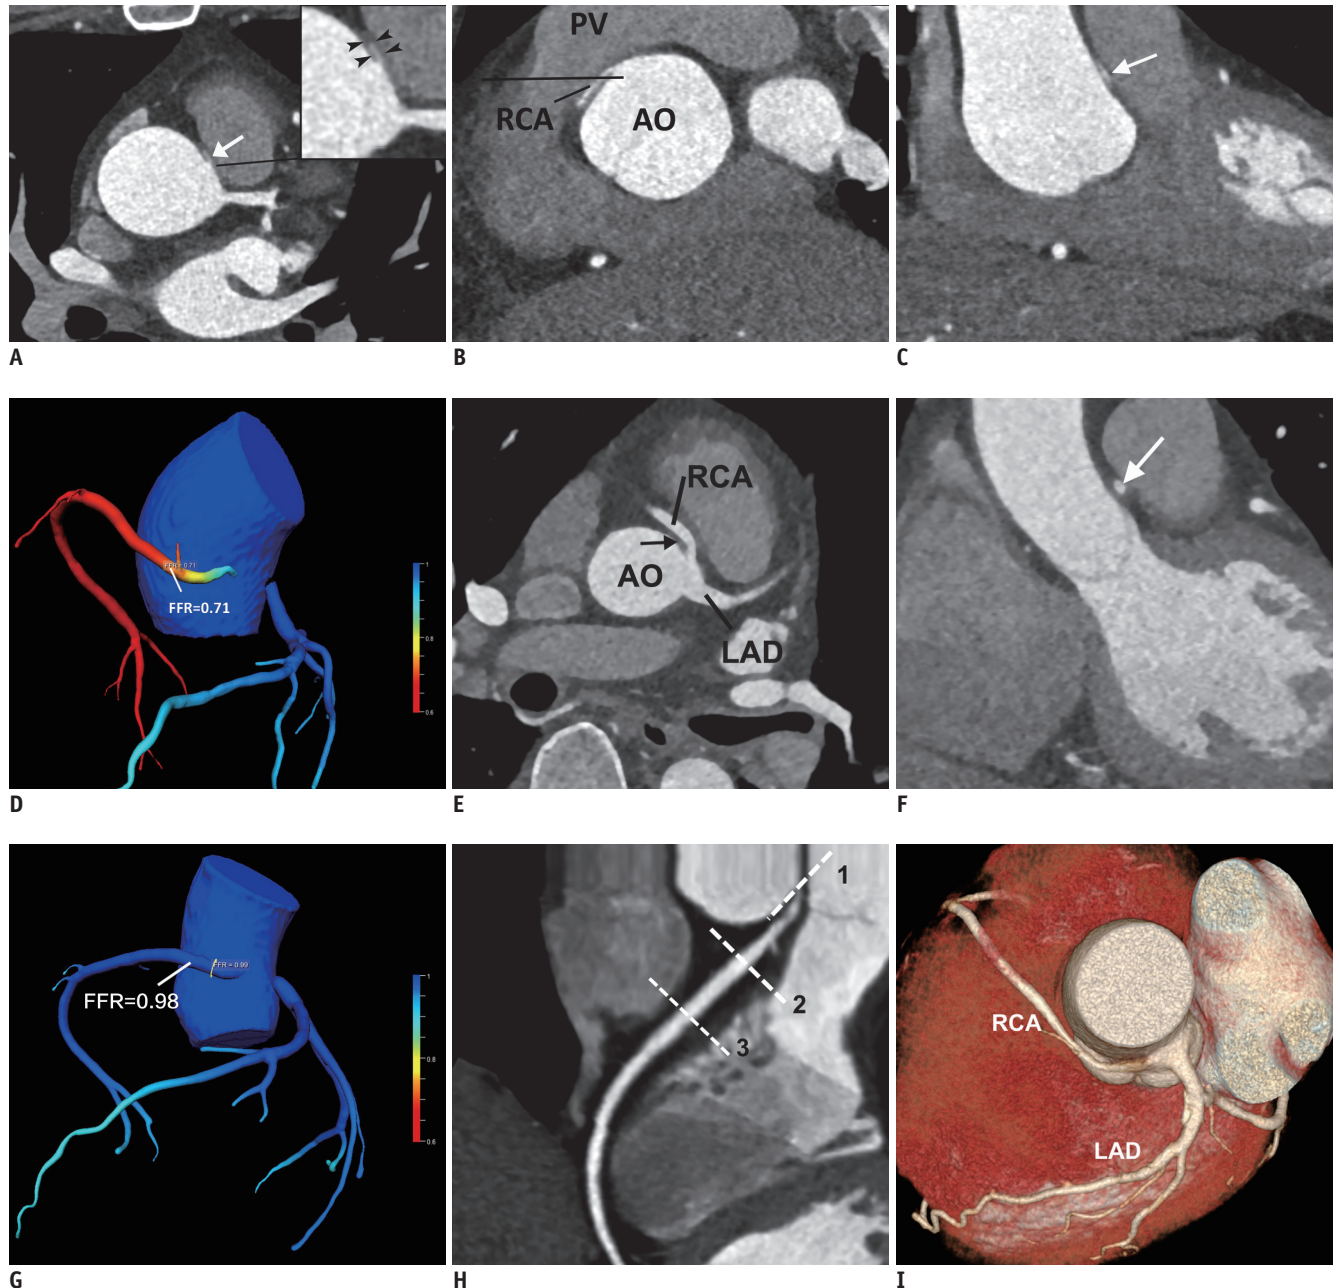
Representative cases of R-ACAOS with interarterial course R-ACAOS with interarterial course in 54-year-old man presenting with typical angina (A-D) and 49-year-old man without any complaint (E-G). A. Displays separate RCA ostia with acute take-off angle (arrow). Absence of adjacent epicardial fat in magnified view (arrowheads) suggests proximal intramural course of RCA. B. Shows take-off level of RCA above PV (line) in coronal view. C. Orthogonal cross-sectional image shows classic slit-like RCA proximal segment configuration (arrow). D. CT-FFR value of proximal RCA is 0.71, implying ischemia resulting from R-ACAOS with interarterial course. E, F. Show R-ACAOS with no intermural course, epicardial fat (arrow in E), and oval ostium in orthogonal cross-sections (arrow in F) with CT-FFR value of 0.98 (G). H. Shows location of CT-FFR measurement in R-ACAOS in our study; line 1 is located at RCA ostia, entrance of anomalous origin of RCA, while line 2 lies at exit, indicating lumen narrowing of proximal RCA from line 1 to line 2. CT-FFR values were measured at site of line 3, 1–2 cm distal to lumen narrowing segment of proximal RCA. I. Displays volume rendering image of R-ACAOS. AO = aorta, CT-FFR = FFR derived from computed tomographic angiography, FFR = fractional flow reserve, LAD = left anterior descending artery, PV = pulmonary valve, R-ACAOS = RCA from left coronary sinus, RCA = right coronary artery
